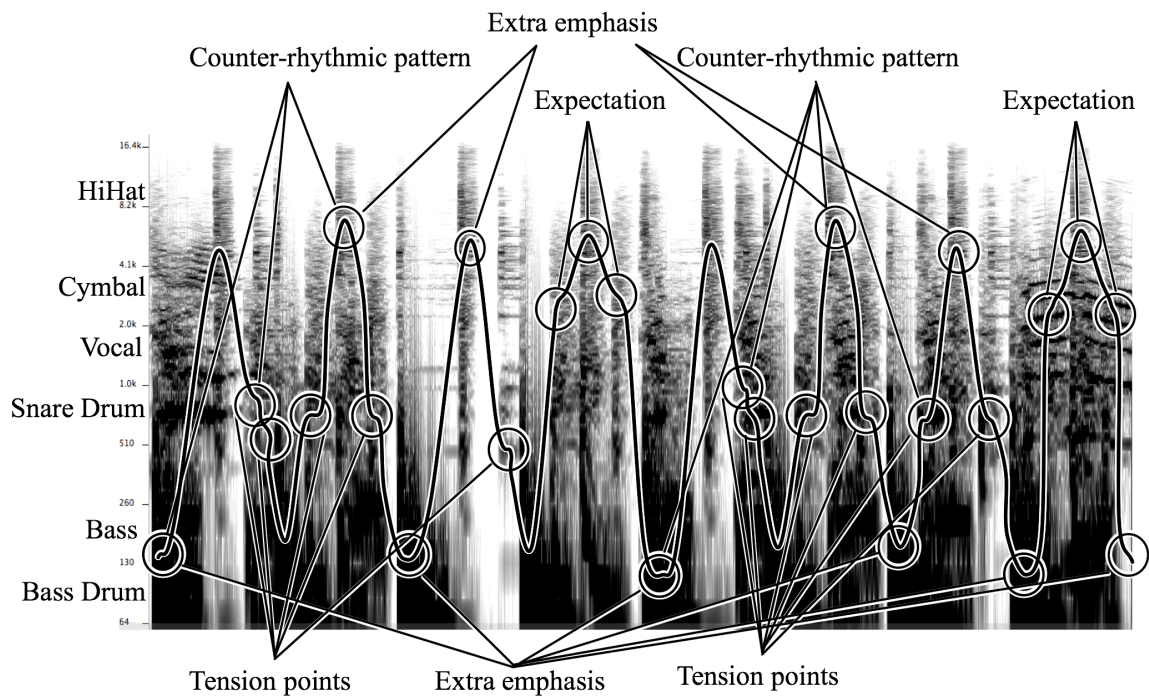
Sonogram of Basement Jaxx's *Jump n' Shout*, 0:33–0:37, with a suggested movement curve and circled possible tension points, emphasized beats, events producing expectation, and counter-rhythmic patterns.
